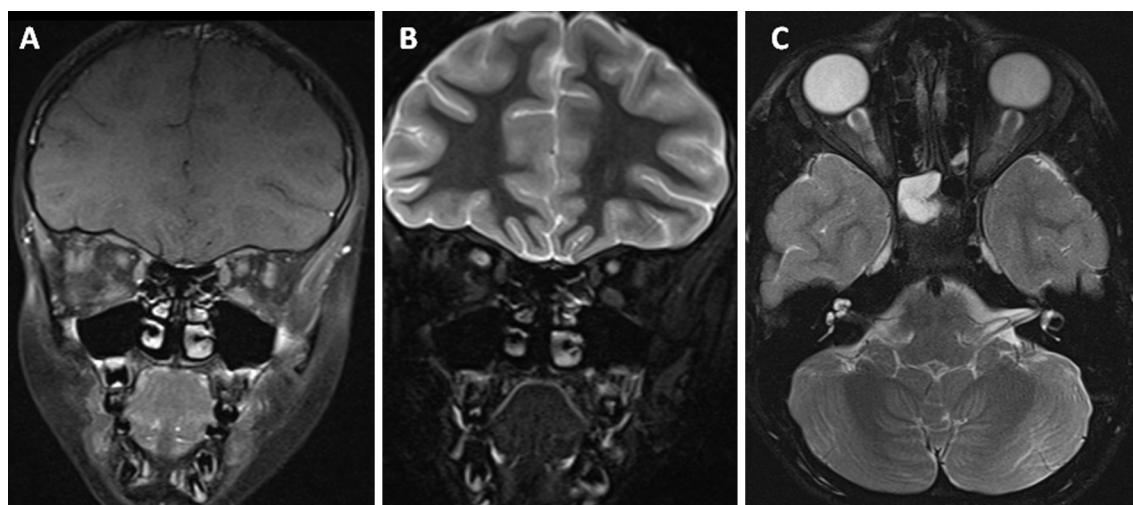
(A) Post-contrast fat-suppressed coronal T1-weighted image. There is no enhancement of optic nerve and meningeal sheaths after gadolinium administration. Optic nerve sheath appears increased in size, bilaterally. (B) Fat-suppressed coronal T2-weighted image demonstrates a high signal intensity area around the optic nerve and confirms that optic nerve sheath is abnormally increased in size, bilaterally. (C) Fat-suppressed axial T2-weighted image shows that the high signal intensity area around the optic nerves is associated with tortuosity of the course of optic nerve sheath and mild flattening of the posterior pole of ocular globe, bilaterally.
